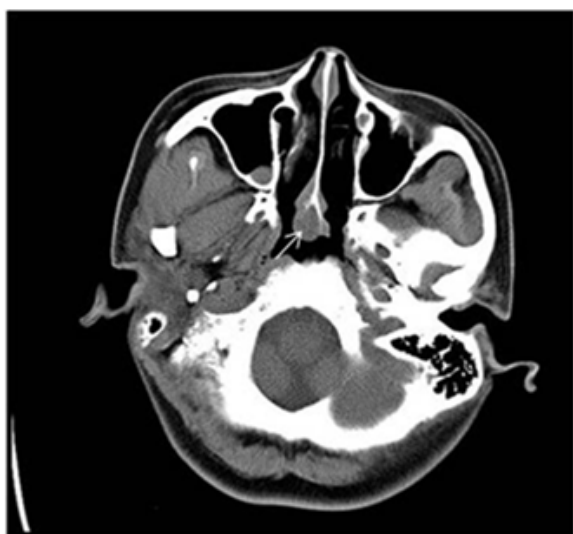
CT showed hypertrophy of the inferior turbinate.
